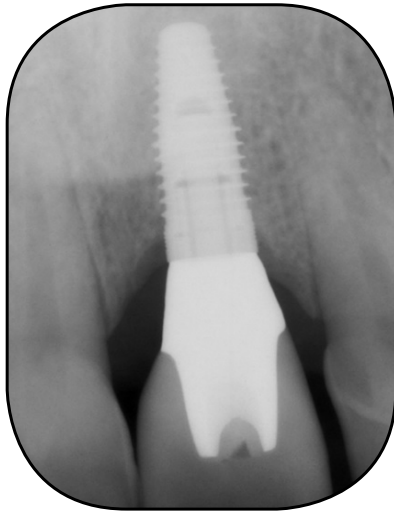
Radiograph showing integrated implant with completed restoration
